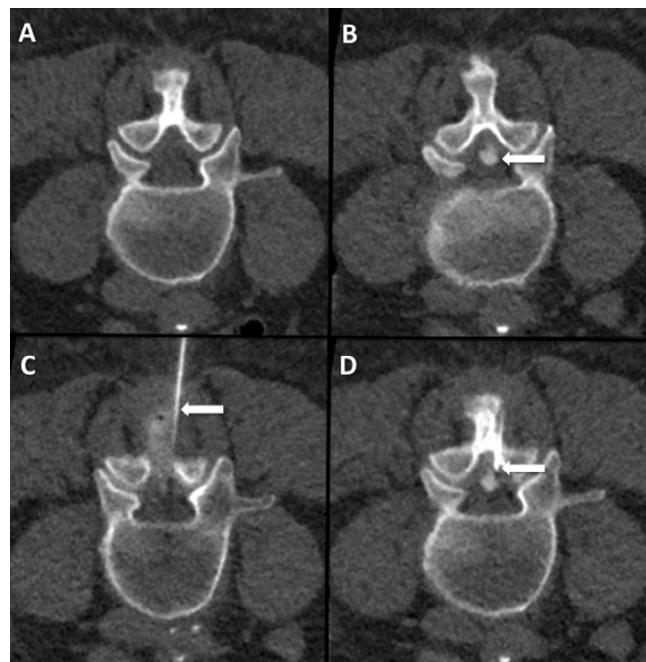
(A) Non-contrast axial computed tomography (CT) fails to demonstrate the posterior epidural cyst. (B) Intra-procedural axial CT demonstrates indirect opacification of the cyst (arrow) after contrast injection into the interspinous bursa. (C and D) Contiguous intra-procedural axial CT images demonstrate the oblique trans-laminar needle (arrows) approach to the central posterior epidural cyst.
